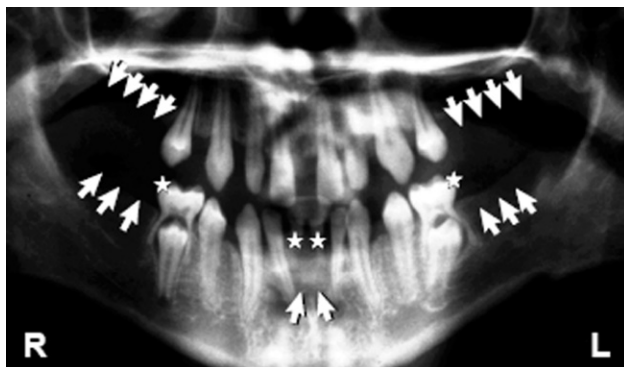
A panoramic radiograph of the dentition of a 13-year-old individual V:5; arrowheads indicate missing teeth, and stars indicate persistent primary teeth.
